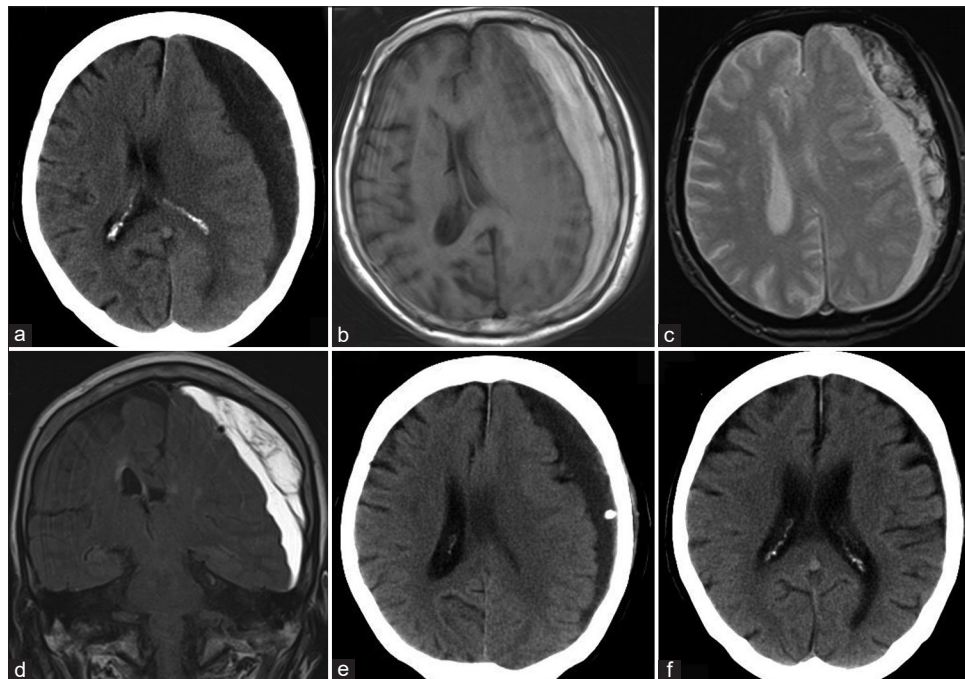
A 74-year-old woman with the left CSDH (a) the preoperative CT scan reveals a mixed density subdural hematoma with a midline shift, (b) hematoma showing hyperintensity on T1WI, (c) the presence of black bands on T2*-weighted images implies the presence of septa within the hematoma cavity, (d) the preoperative hematoma volume was 173 mL, as measured on fluid-attenuated inversion recovery coronal images, (e) CT scan 1 day after surgery revealing little air collection in hematoma cavity. The drainage rate was 36%. (f) The subdural hematoma disappeared 2 months after surgery. The patient recovered completely from right-sided hemiparesis in this case. CT: Computed tomography, CSDH: Chronic subdural hematoma.
